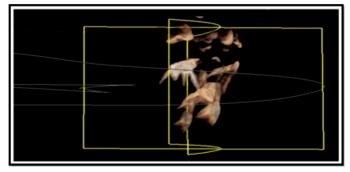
Showing post operative CBCT of 85.
